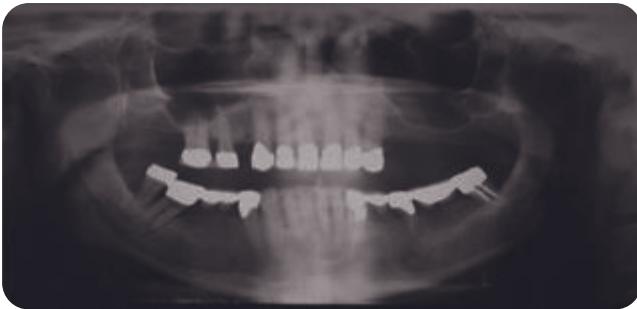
Pretreatment panoramic radiograph. The lower edentulous areas have acceptable vertical height for implant placement but inadequate buccal-lingual width. Also note the size of the maxillary sinus.
